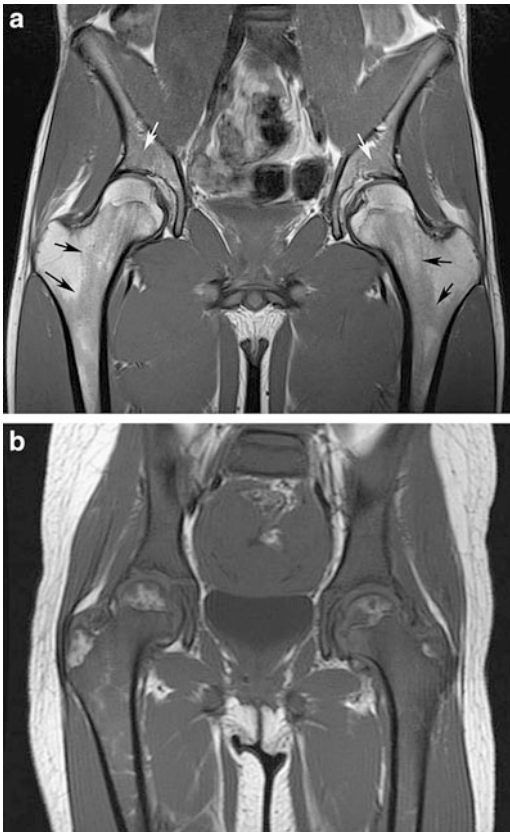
(a) Coronal T1-weighted image through the pelvis and hips in a 17-year-old male with history of right hip pain reveals a normal marrow pattern, with predominantly fatty marrow with geographic or “flame-shaped” regions of residual hematopoietic marrow within the femoral metadiaphyseal region (*black arrows*) and superior acetabulum (*white arrows*). (b) The marrow is nearly completely replaced with intermediate signal intensity lesions on this T1-weighted image through the pelvis in an 8-year-old female with newly diagnosed leukemia
